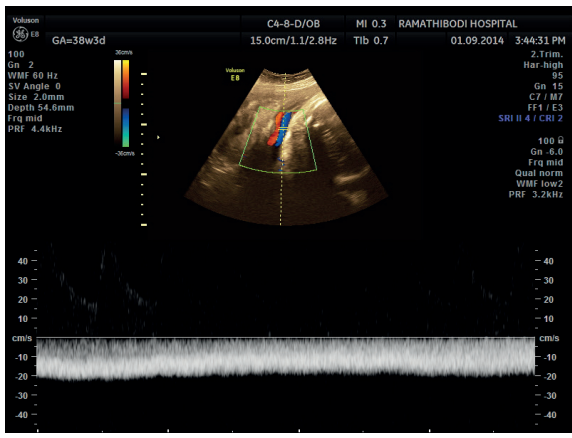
Measurement of umbilical venous Doppler.
